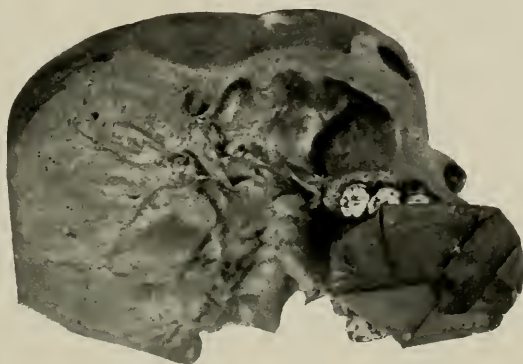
As a film is placed in the mouth for the pose and radiograph shown in Fig. 89.
